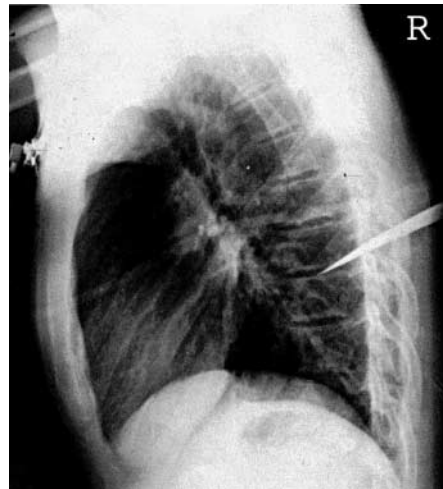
Lateral chest radiograph
